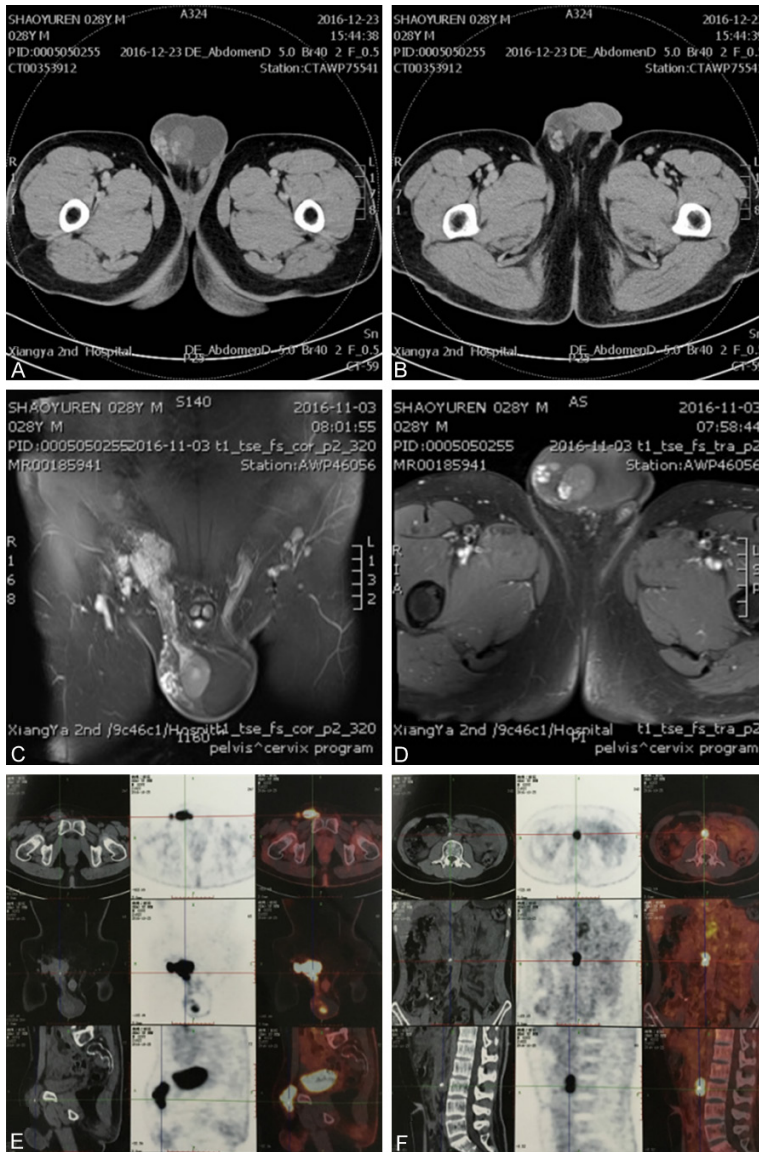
A. CT of the testis paraganglioma. Multiple nodules in the right testis with hydrocele of tunica vaginalis. B. CT of the spermatic cord paraganglioma. A round-like lump in the right spermatic cord with clear boundary. C. MRI coronal section of the spermatic paraganglioma. D. MRI cross section of testis and spermatic cord paraganglioma. E. PET-CT imaging of spermatic cord and testis paraganglioma. A round-like lump of increased glucose metabolism in right spermatic cord with clear boundary. F. PET-CT imaging of retroperitoneal lymph node. Increased glucose metabolism nodules and masses in the retroperitoneum.
